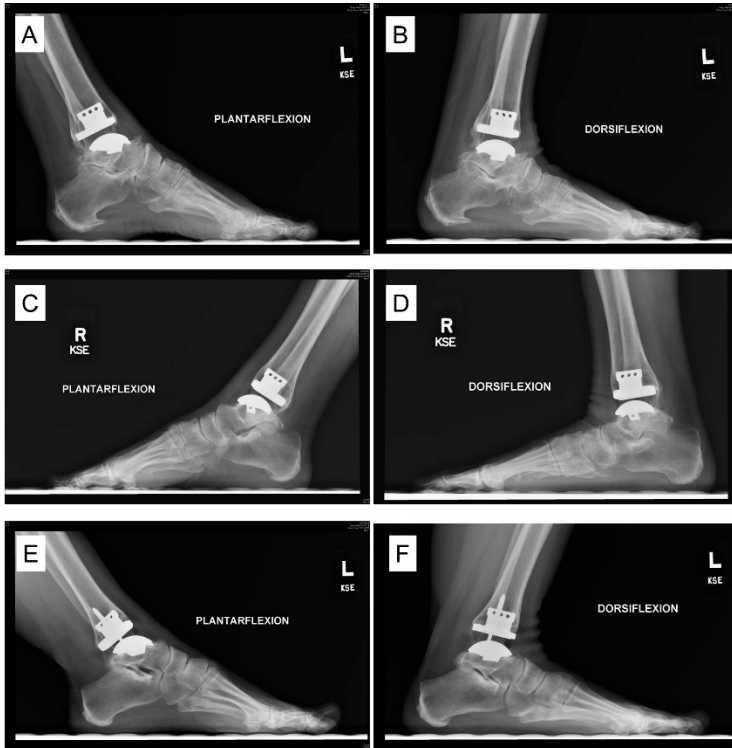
Plantar flexion and dorsiflexion radiographs demonstrating primary additional contribution to ankle motion from the midfoot (A and B), the talonavicular joint (C and D) and the subtalar joint (E and F).
